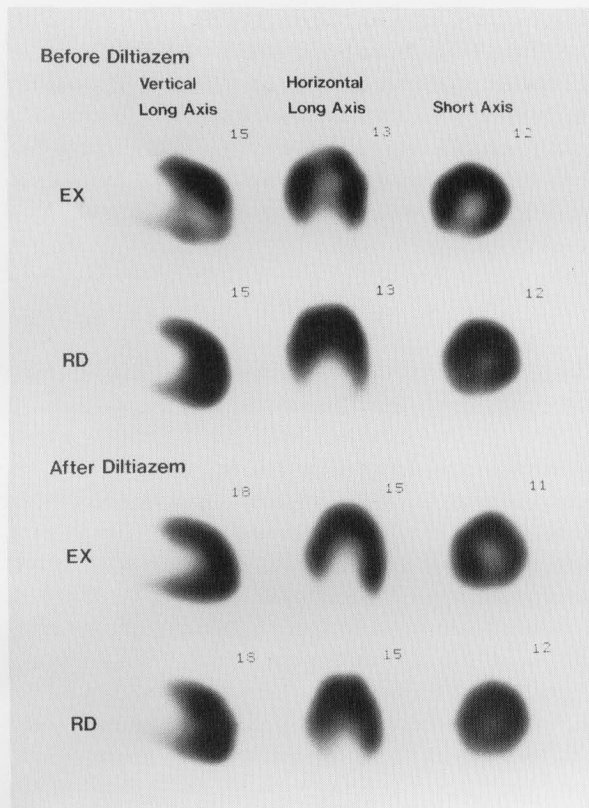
Exercise ^{201}Tl SPECT images before (upper) and after diltiazem treatment (lower) in a 56-year-old man with hypertrophic cardiomyopathy. Before diltiazem administration, myocardial perfusion decreased in the septal portion of the posterior wall and the apex during exercise and redistribution is observed in these regions after 3 hours of rest. Myocardial perfusion improved in these regions during exercise after diltiazem treatment.
